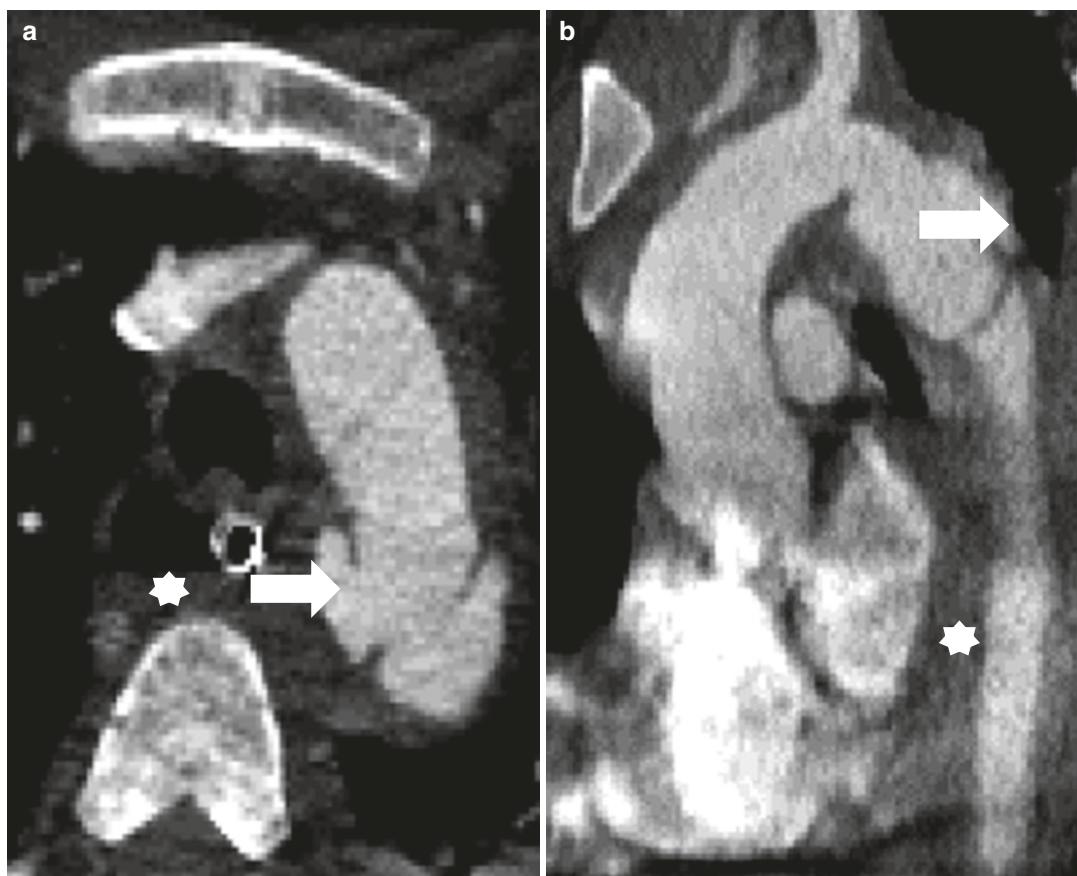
Twenty two-year-old woman presenting after a motor vehicle collision. Axial (a) and sagittal (b) IV contrast-enhanced CT images of the thoracic aorta show
